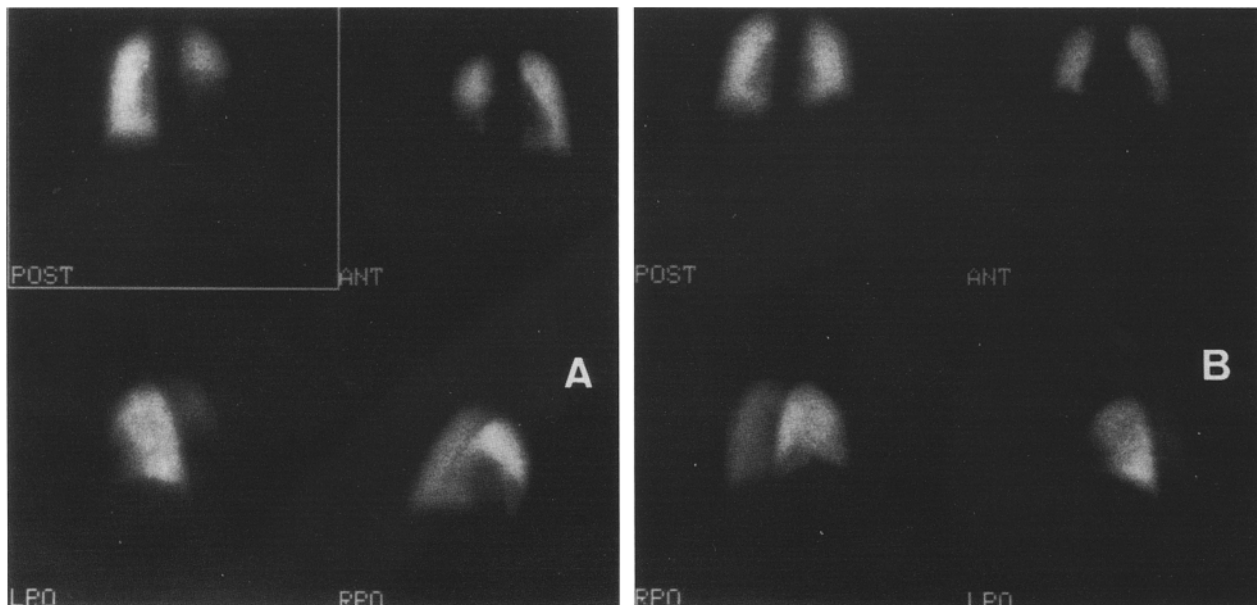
$^{99\text{m}}\text{Tc}$ -MAA perfusion lung scintigraphy: inhalation of a foreign body in a 4-year-old child. A Before removal of the foreign body, the right lower and middle lobes are not visualized.
